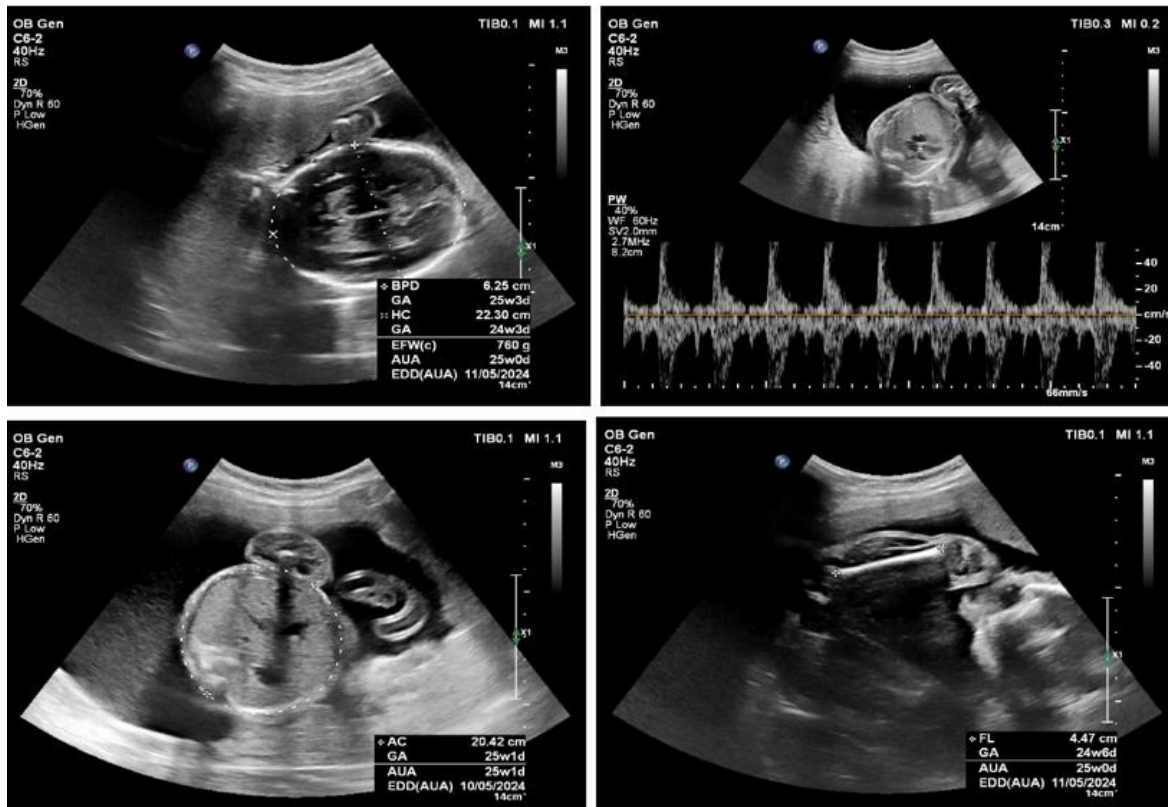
Ultrasound result showed a fetal image.
